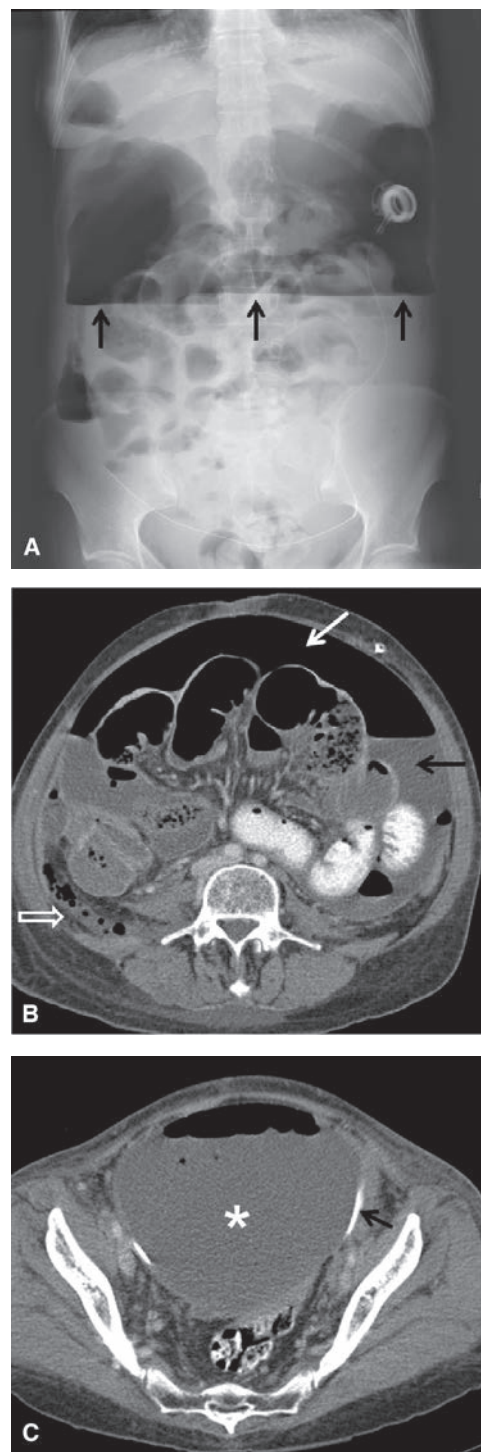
A 53-year-old woman with recurrent papillary serous carcinoma of the ovary with serosal bowel implants undergoing treatment with intraperitoneal chemotherapy presents with abdominal pain, vomiting and fever: A: Upright abdominal radiograph demonstrates large amount of free intraperitoneal air with air-fluid level due to the presence of ascites fluid (arrows). Multiple dilated air-filled loops of bowel are noted. Intraperitoneal chemotherapy infusion catheter is in place with port in left upper abdomen. These findings are compatible with perforated viscus. B: Axial contrast enhanced CT scan in the same patient demonstrates a large amount of free intraperitoneal air (white arrow) and ascites fluid (black arrow). There are multiple dilated loops of bowel. There is a mottled gas collection in the right lower quadrant posterior to the cecum (open white arrow). At surgery, the cecum was found to be perforated. C: Large loculated fluid and gas-containing collection in the pelvis is compatible with an abscess (*). The chemotherapy infusion catheter is visualized at the posterior wall of the abscess (black arrow).
